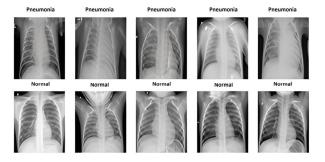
Chest X-ray images (pneumonia/normal) [28]
